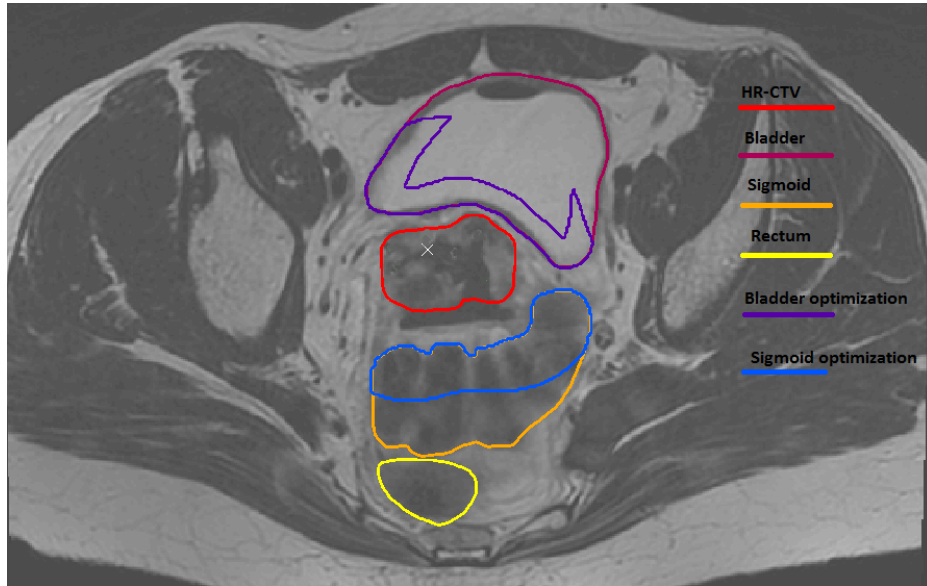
The optimization structures projected on a delineated MRI of a patient. To speed up computations, *Bladder optimization* and *Sigmoid optimization* were used for optimization instead of *Bladder* and *Sigmoid*. *Rectum optimization* is not shown in this slice.
